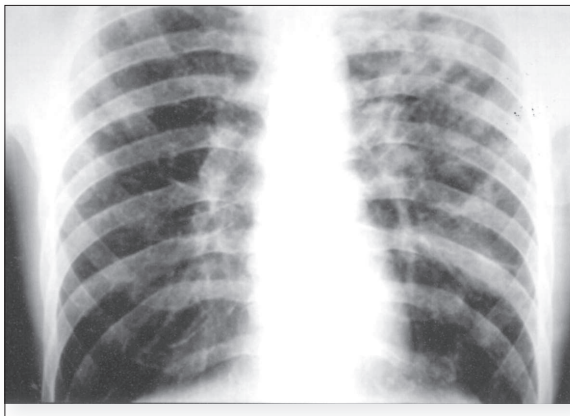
Chest X-ray showed micronodular infiltrates
